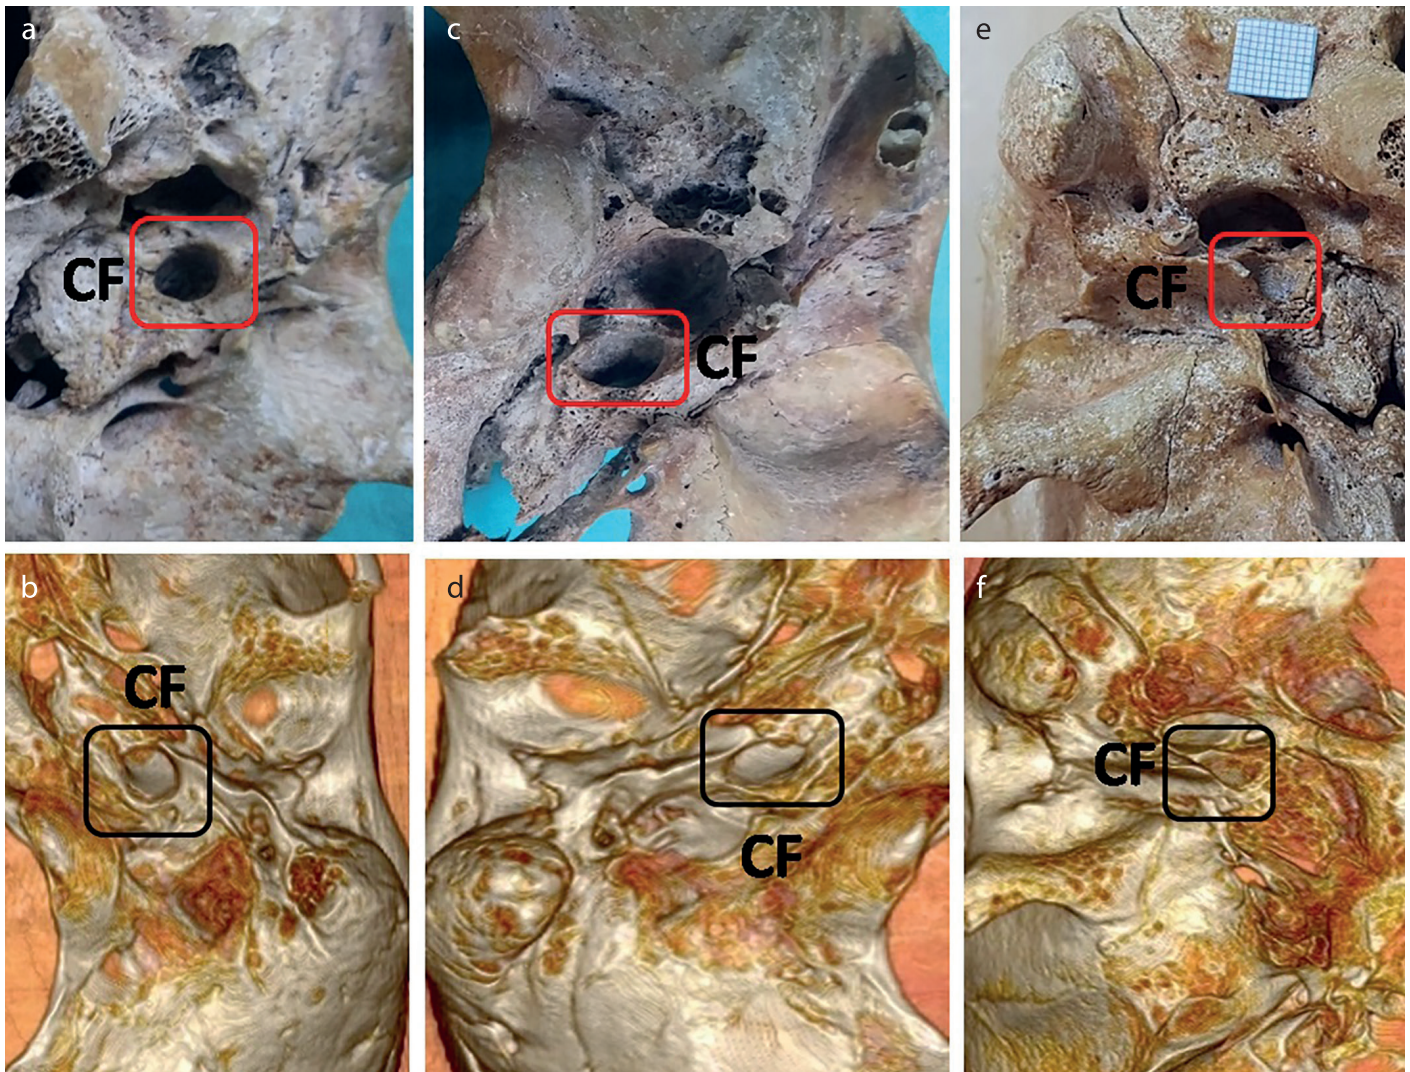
a-f. The photographs show the shape of CF in dry skulls and CT. a, b) round shaped, c, d) oval shaped, and e, f) tear-drop shaped.
